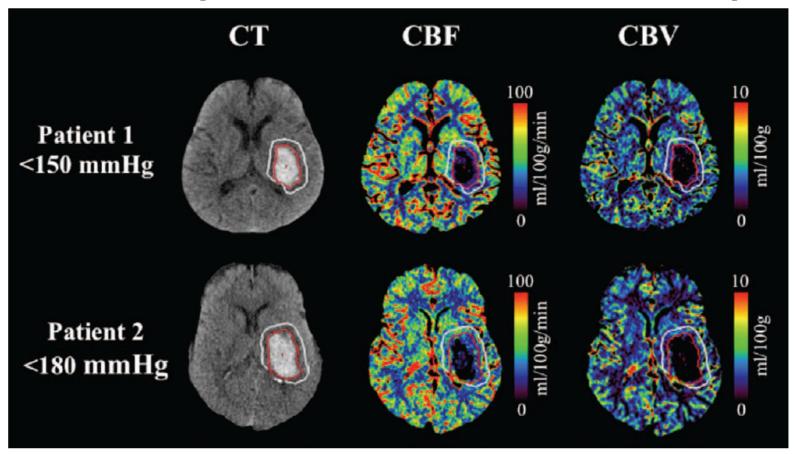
Examples of cerebral blood flow (CBF) and cerebral blood volume (CBV) maps and corresponding computed tomography (CT) images in patients after acute blood pressure reduction to <150 mm Hg (top) and <180 mm Hg (bottom). Hematoma (red) and perihematoma (white) regions of interest are demonstrated on all slices. Reductions in CBF are evident in the perihematoma region of both patients.
